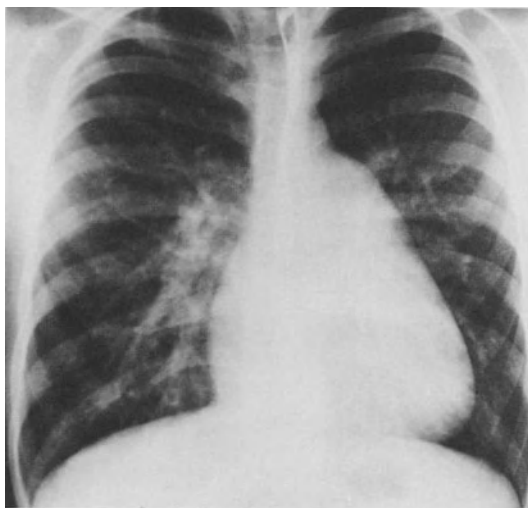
The X-ray in secundum atrial septal defect with large left-to-right shunt and low pulmonary vascular resistance. Pulmonary plethora is particularly evident in the right lung field and the arteries extend to the periphery.
